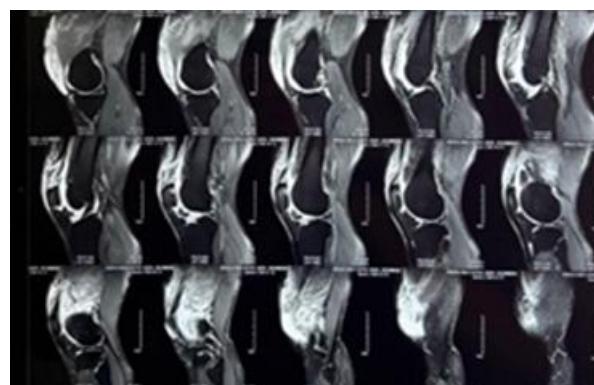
(a): Sagittal PD-FS MRI demonstrating complete quadriceps tendon tear with retraction
